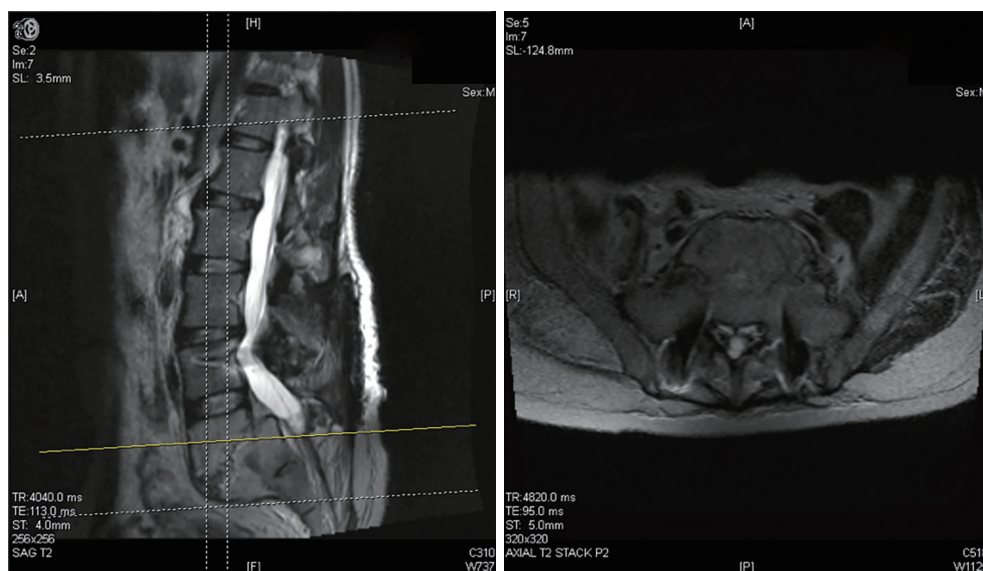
Repeat T2-weighted MRI imaging of lumbar spine (L5-S1) at 15 months post-operation. MRI, magnetic resonance imaging; TR, repetition time; TE, echo time.
